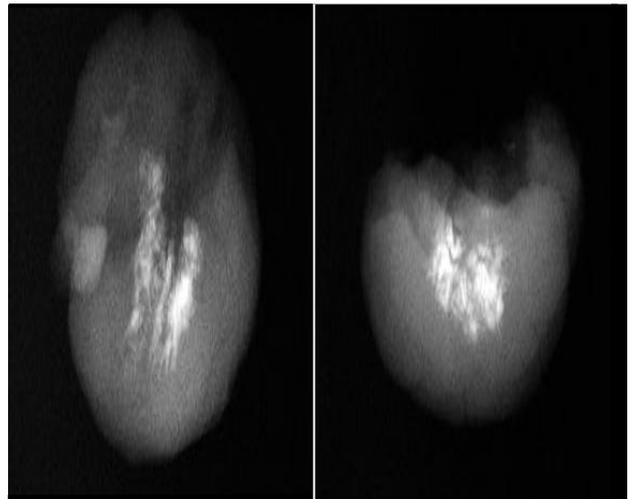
Radiograph of the excised lesion showing central areas of calcification.
